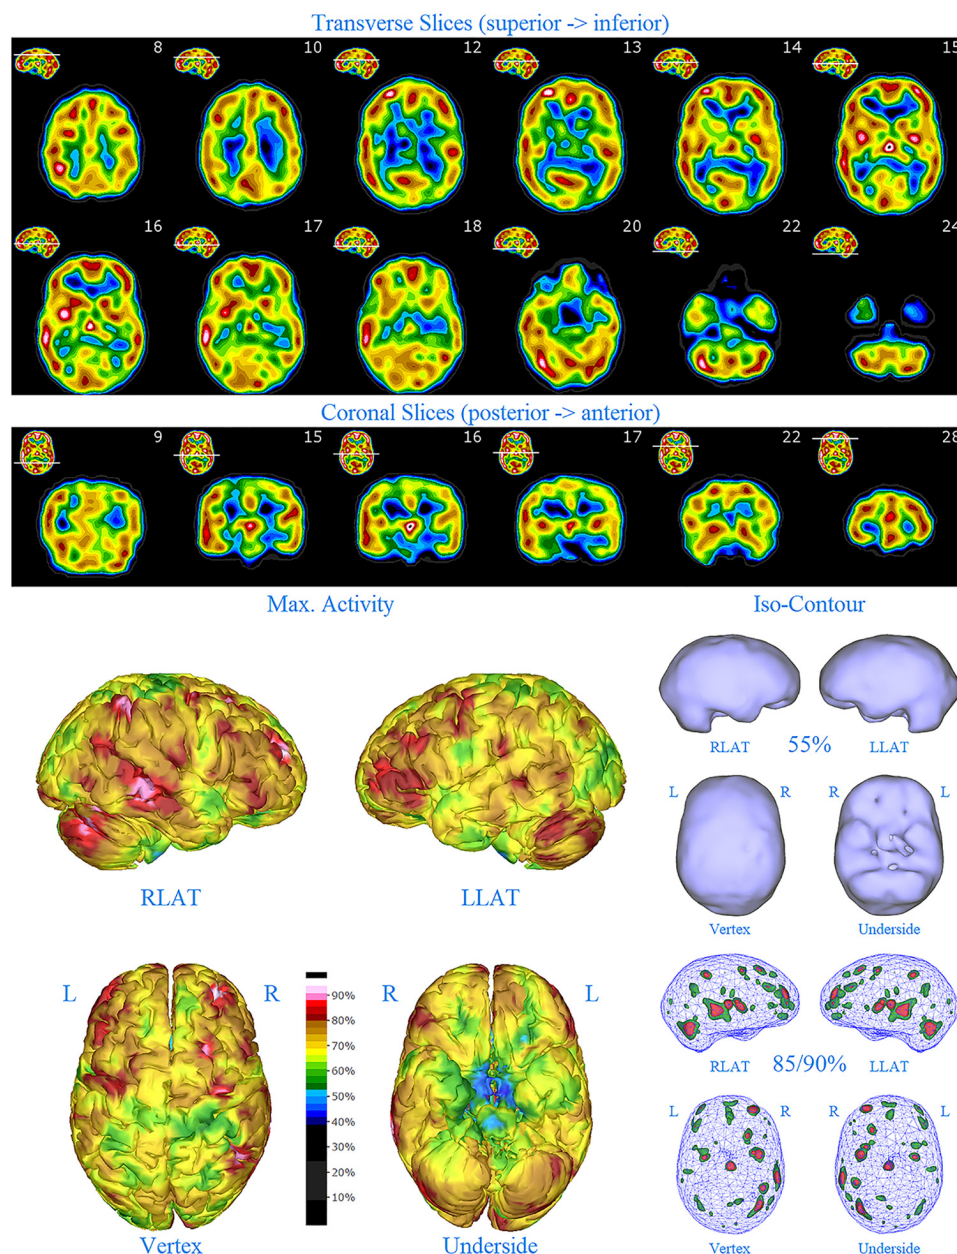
Second perfusion SPECT scan of Patient D. Arrangement, color scales, and views are identical to Figure 1. Anatomical structures such as the thalamus are positioned similarly to the scan shown in Figure 2. Labeling was eliminated to avoid obscuring the scan details. Perfusion of the thalamus is intensely increased and asymmetrical. Areas of increased perfusion in the cerebral cortices are considerably less prominent.
